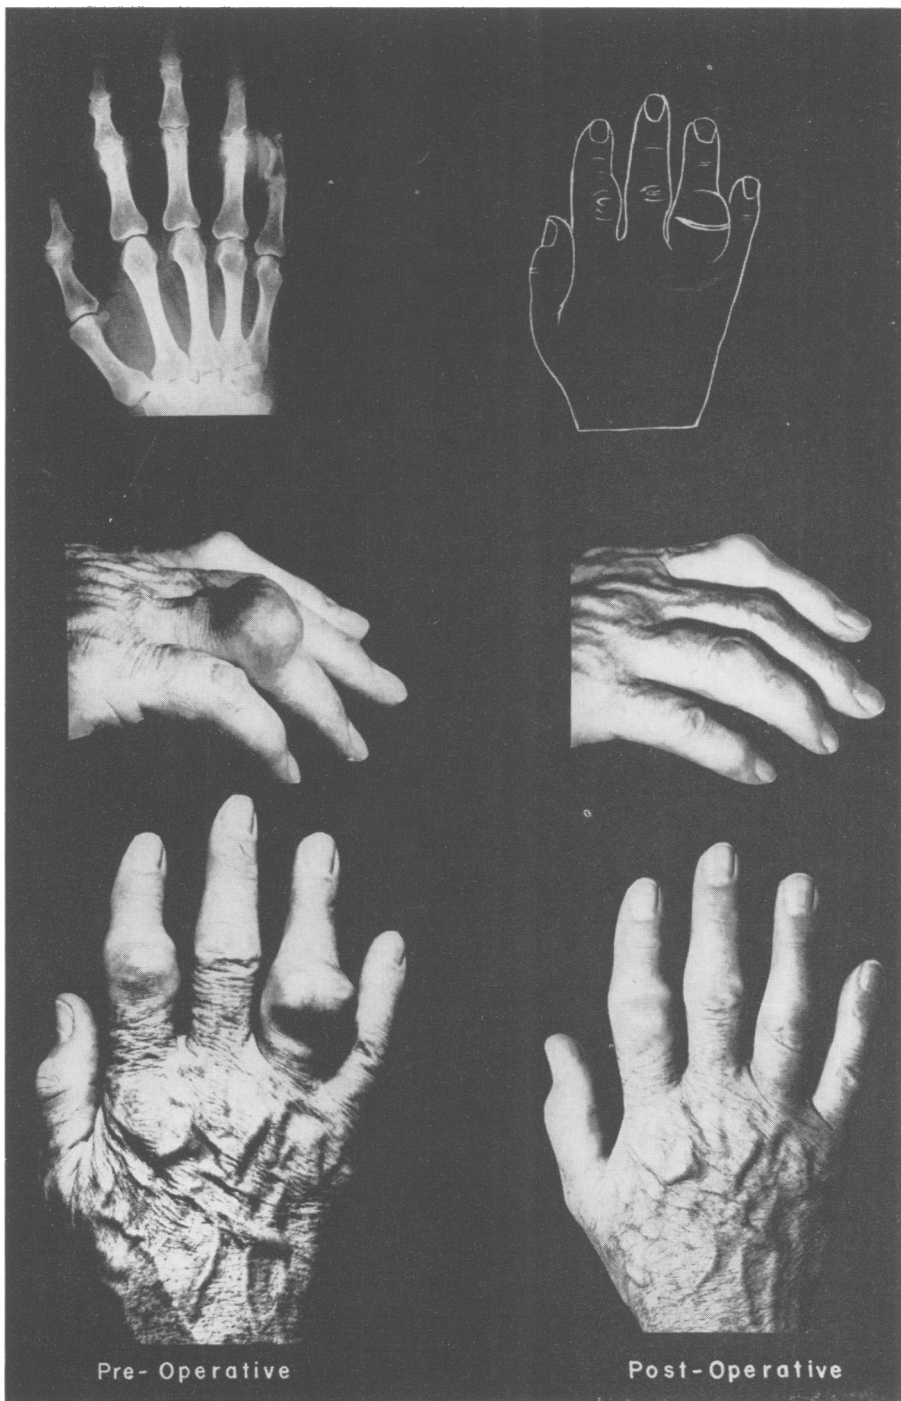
Tophaceous deposits involving the index and fourth fingers of the right hand. The patient, a male, age 69, had symptoms of gout for 15 years (The same patient as in Fig. 9). The roentgenogram shows moderate involvement of the bones. Only the tophus on the fourth finger was removed, at the patient's request, but since he obtained such a satisfactory result on this one he is planning to have the one on the index finger removed. The operation was performed under novocain block anesthesia at the base of the finger. The tophus was removed through a transverse incision. It involved the extensor tendon but it was possible to preserve a portion of it so it was only necessary to splint the finger until the wound healed. The interphalangeal joint capsule and the cartilages were involved. The patient was pleased with the cosmetic result, volunteering the information that he no longer tried to hide his hand while in public. The photographs show the hand before operation and four months later.
